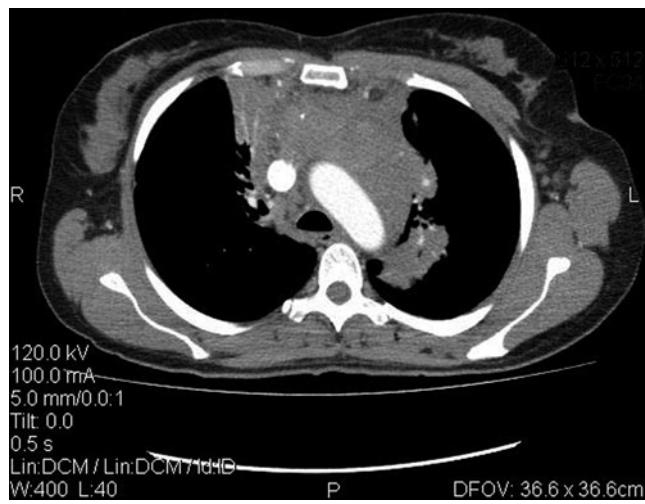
CT scan of the same patient shows a large anterior mediastinal mass measuring 4.2 cm in its AP diameter. There is no obvious compression of the major airways or vascular structures. GA was uneventful and included a conventional intravenous induction with propofol and paralysis with succinylcholine for intubation. Biopsy eventually revealed a diagnosis of recurrent Hodgkin's lymphoma.
